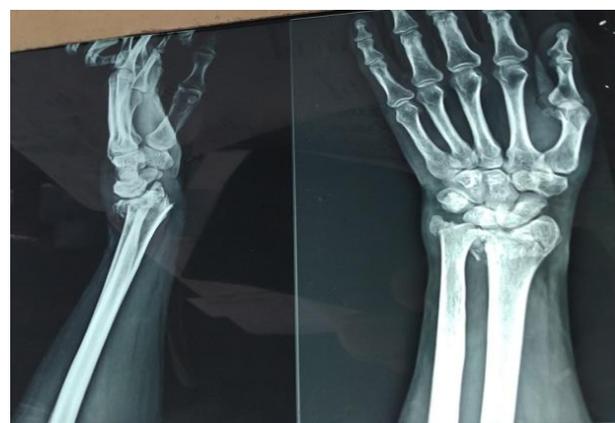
Pre-op lateral and AP X-ray.
